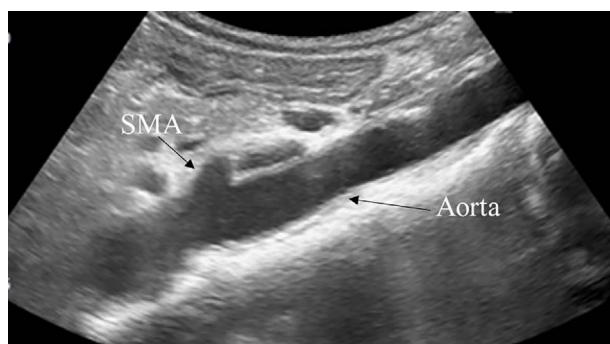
An abdominal sagittal ultrasonography image for measuring the angle between the SMA and aorta. SMA: superior mesenteric artery
